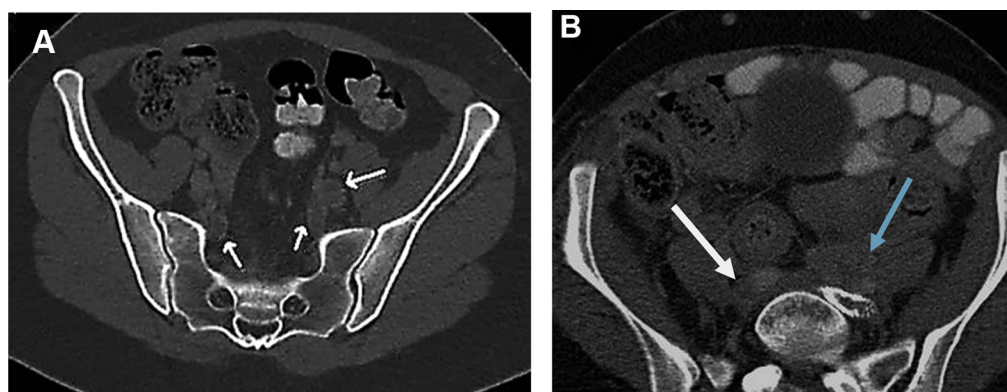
(A) Computed tomography (CT) venogram revealed initially thrombosed right internal iliac vein (arrow) at the same time as left iliofemoral deep venous thrombosis. (B) CT venogram showing left ovarian cancer compressing the left common iliac vein (CIV) stent with thrombosed right CIV (arrow).
